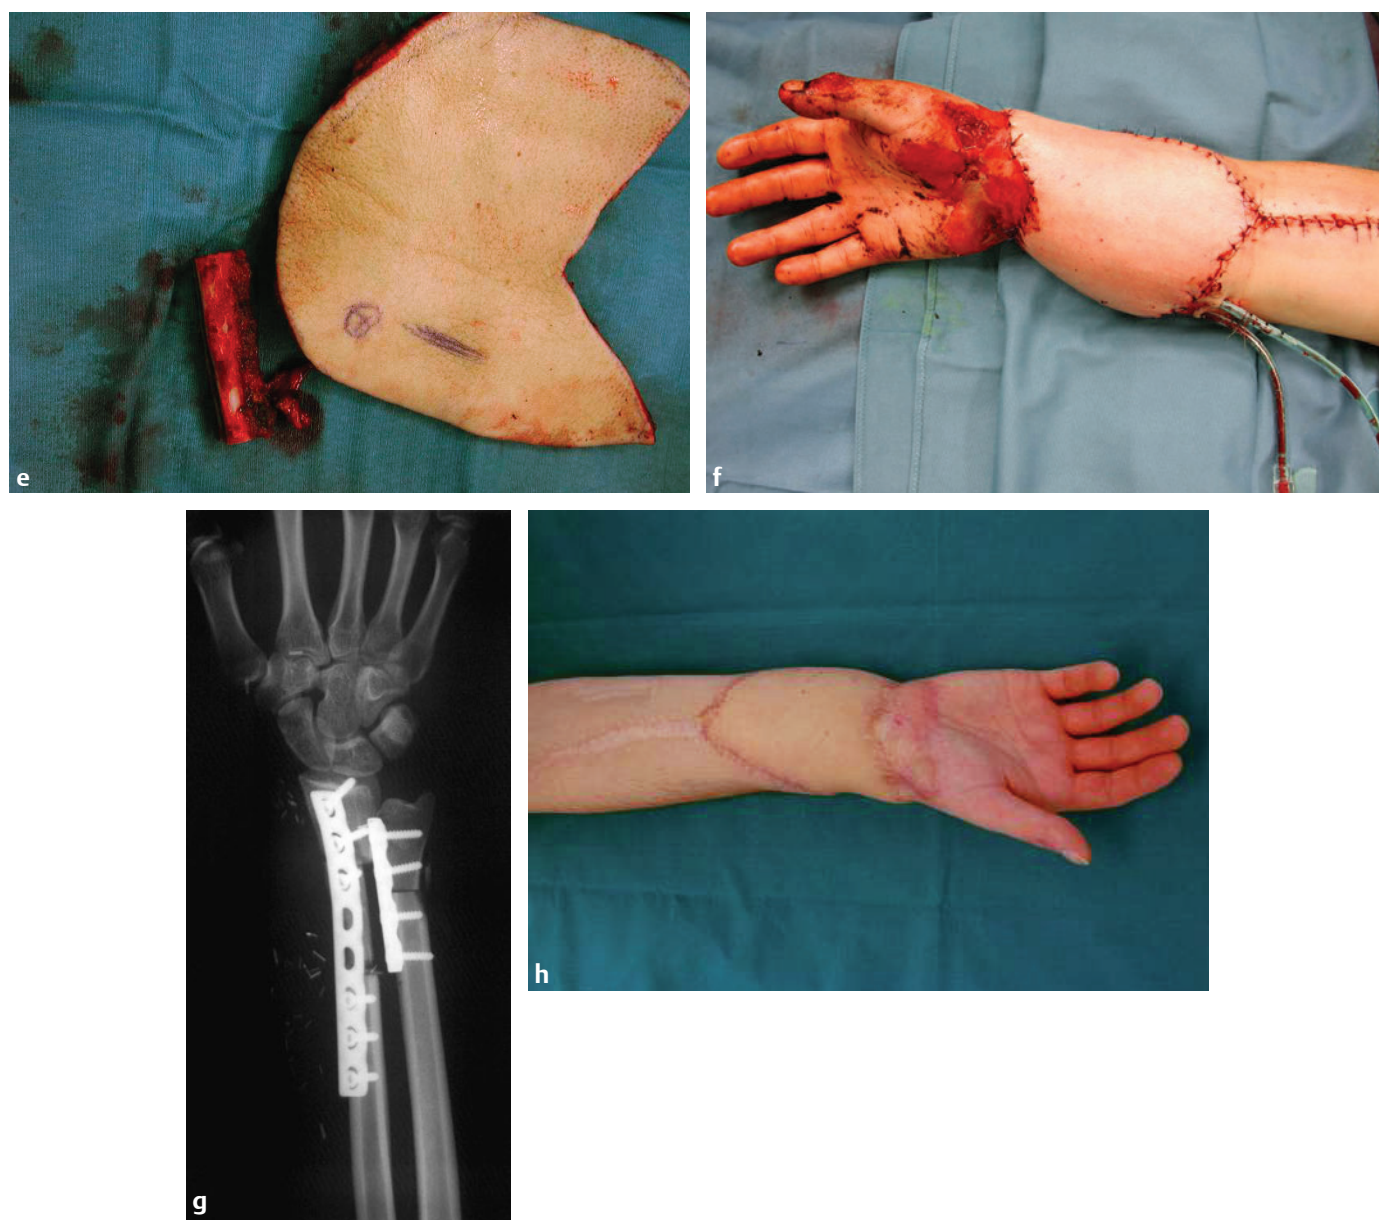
(*continued*) (e) The patient's graft involved a scapular/parascapular flap with a vascularized scapula bone. (f) The postoperative situation after the reconstruction of all defects and the inset of the flap. (g) A radiograph of the patient's arm immediately after surgery, with correct axial positioning of the forearm. (h) One year postoperatively.
